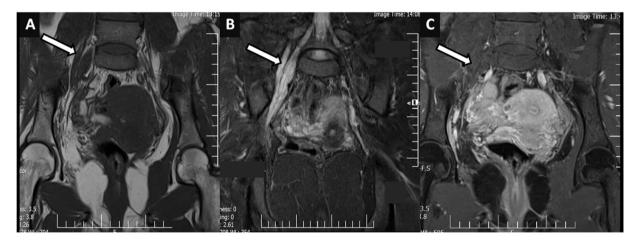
Coronal Magnetic Resonance Imaging (MRI) show fusiform focal thickening and hypertrophy with progressive enlargement of the right lumbosacral plexus and sciatic nerve diameter (white arrow), compatible with either localized hypertrophic neuropathy (LHN) of the sciatic nerve and the lumbosacral plexus: (A) low signal on T1-weighted images; (B) abnormal hyperintensity of the nerves on STIR images; (C) preserved normal fascicular and linear configuration; (C) no enhancement following intravenous gadolinium administration.
